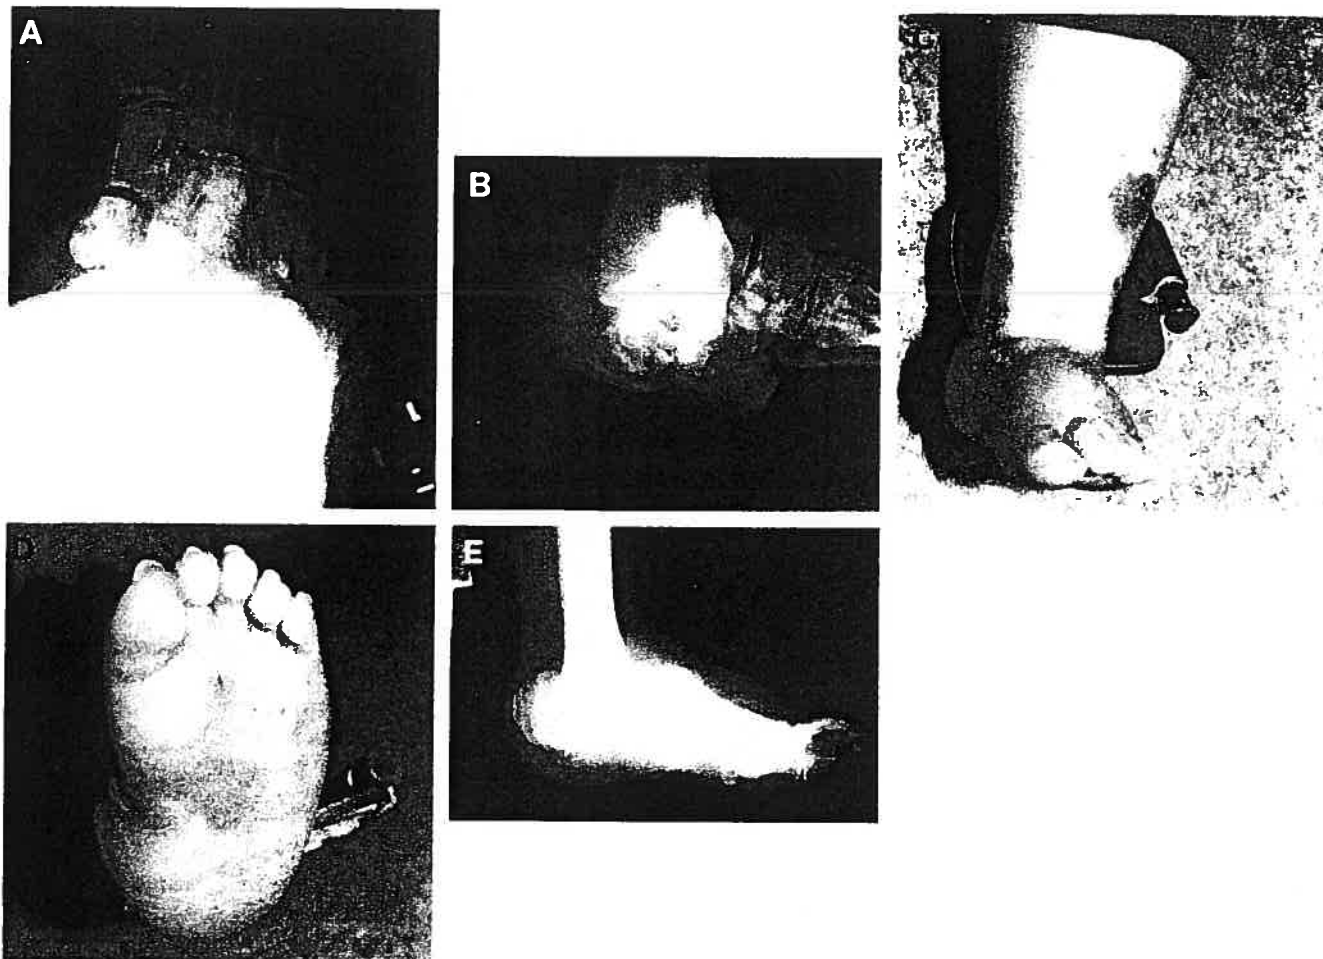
Fifty-seven-year-old, insulin-dependent, blind, 110-kg, type-II diabetic patient with progressive deformity of the ankle that was not controllable with a custom-contoured total contact bivalved polypropylene ankle-foot orthosis (CROW Walker). A, B, weight-bearing radiographs before surgery. Because of persistent post-operative drainage, the nail was removed, weightbearing was allowed in a walking cast, and parenteral culture-specific antibiotics were used for 12 weeks. C, D, Wagner grade 0 foot and (E) radiograph at 1 year after surgery.
